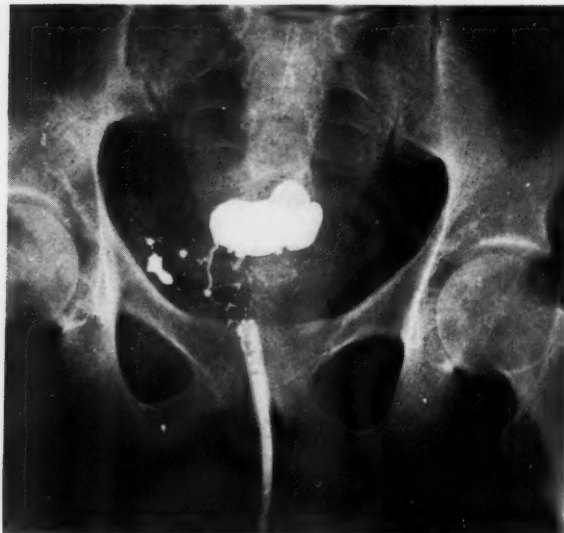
Anteroposterior radiograph after lipiodol injection of the suprapubic sinus. Note the communication along the right side of the pelvis with the large space anterior to the lower end of the sacrum. The top of the catheter lies in the suprapubic sinus.
